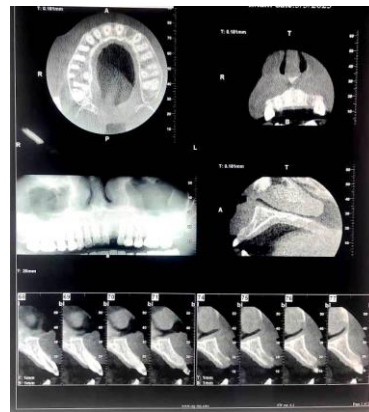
Ragiograph damaged tooth's apical third root fracture (IOPAR & CBCT)
